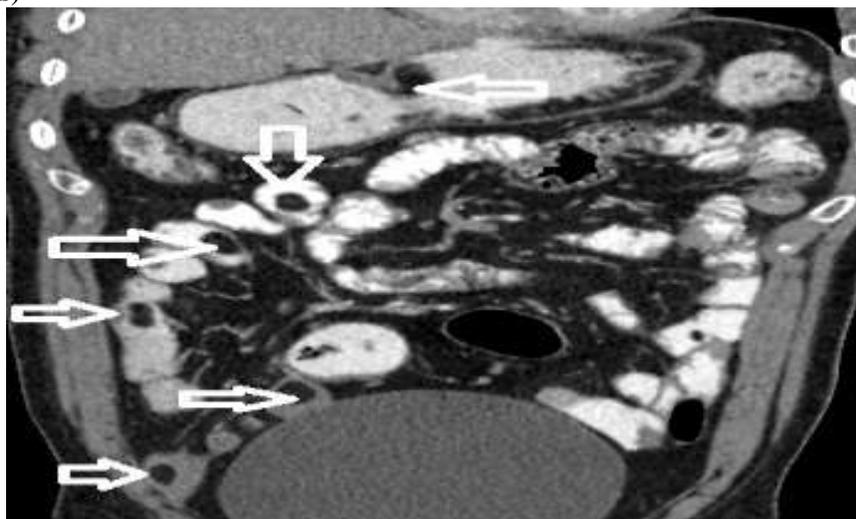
Post contrast CT coronal section reveal multiple ileal loop showing fat attenuation polypoidal sol s/o lipomas (arrows)
